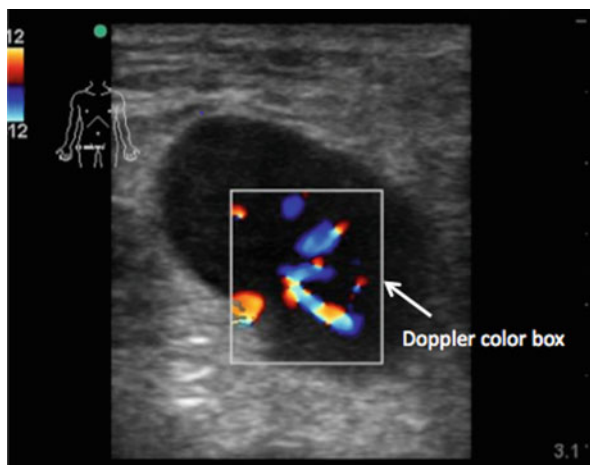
Combined gray scale and color flow Doppler image of a lymph node. Blood flow is only detected within the area of the Doppler color box. Anechoic structures are frequently seen during an ultrasound examination. Color flow Doppler allows the operator to demonstrate whether there is any blood flow in the structure. In the image below, a lymph node demonstrates internal flow compared to an abscess, which can be more irregularly shaped and does not exhibit any color flow
